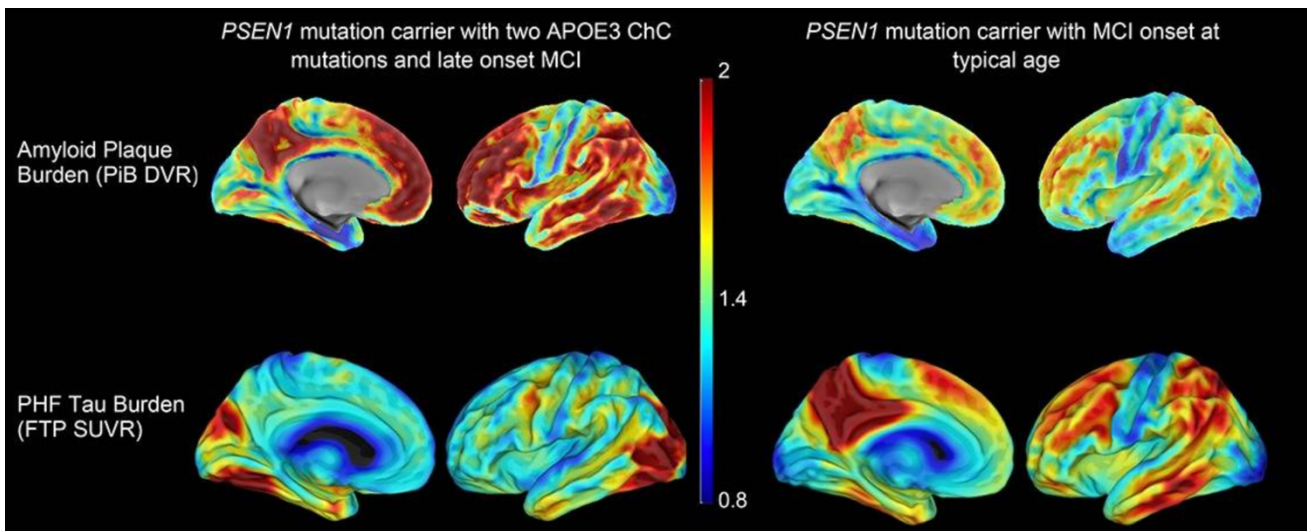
Neuroimaging showed high amyloid and low tau burden in a *PSEN1* carrier who is also homozygous carrier of the *APOE*_ε mutation, compared to a typical *PSEN1* carrier. PET measurements of amyloid burden were taken using the Pittsburgh Compound-B (PiB) and distribution volume ratios (DVR) were calculated. Flortaucipir was used for tau PET and standard uptake value ratios (SUVR) were quantified. Red indicates highest radiotracer binding and blue indicates lowest binding (Arboleda-Velasquez *et al*, 2019).
